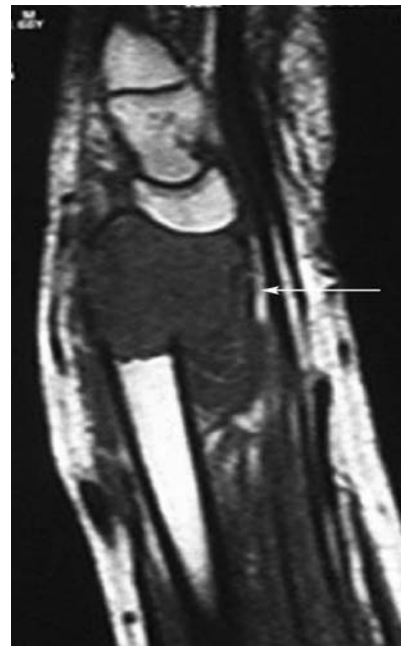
Case9 - MRI of distal radius: Note the soft tissue component in the volar side
